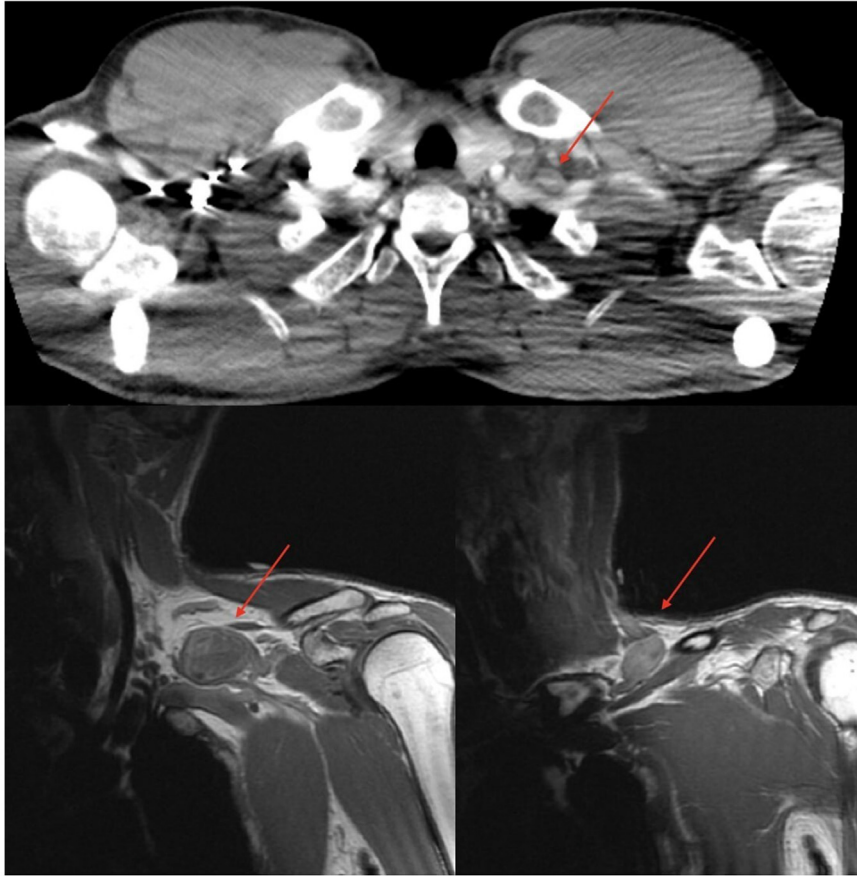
Computed tomography angiography of the chest, axial image, showing a 4.6 × 2.8 × 2.9-cm, ovoid vascular structure off the left subclavian artery, concerning for pseudoaneurysm vs aneurysm. Magnetic resonance angiography of the shoulder, coronal image, displaying a pseudoaneurysm of the left subclavian artery and a focal aneurysmal-like dilatation of the thyrocervical trunk.
